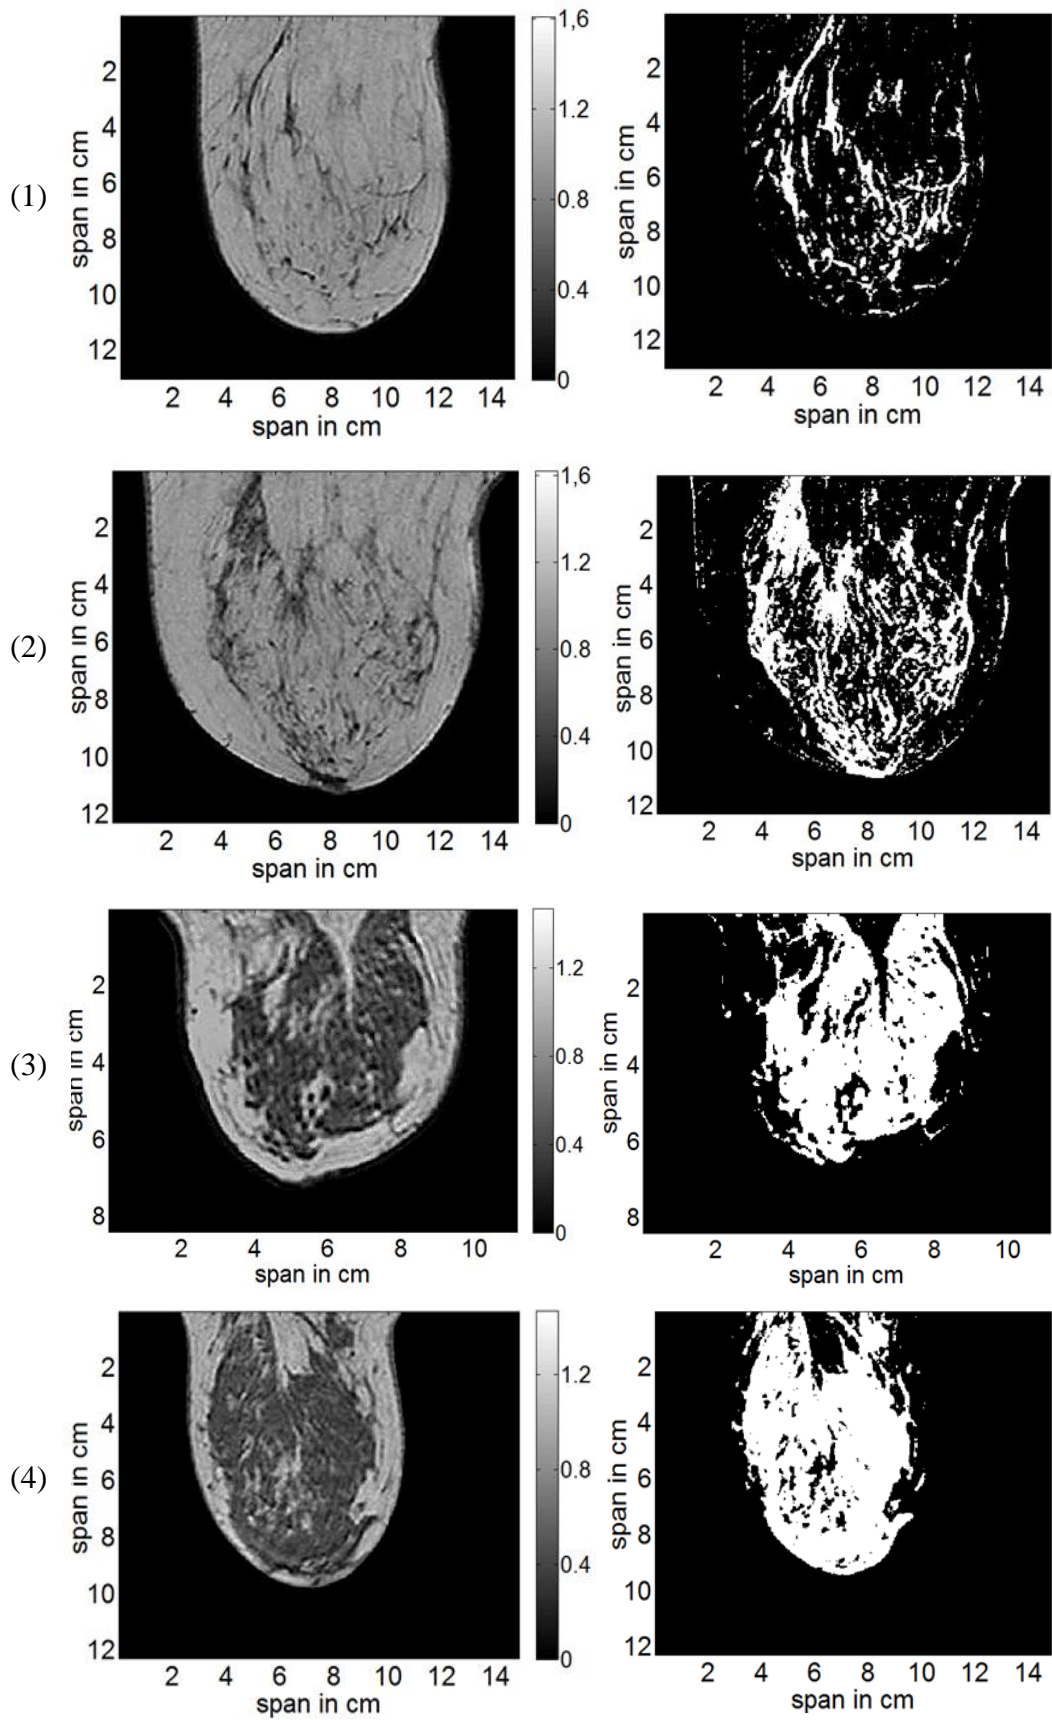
Visual results of segmentation of the breast classified as different radiographic densities.
